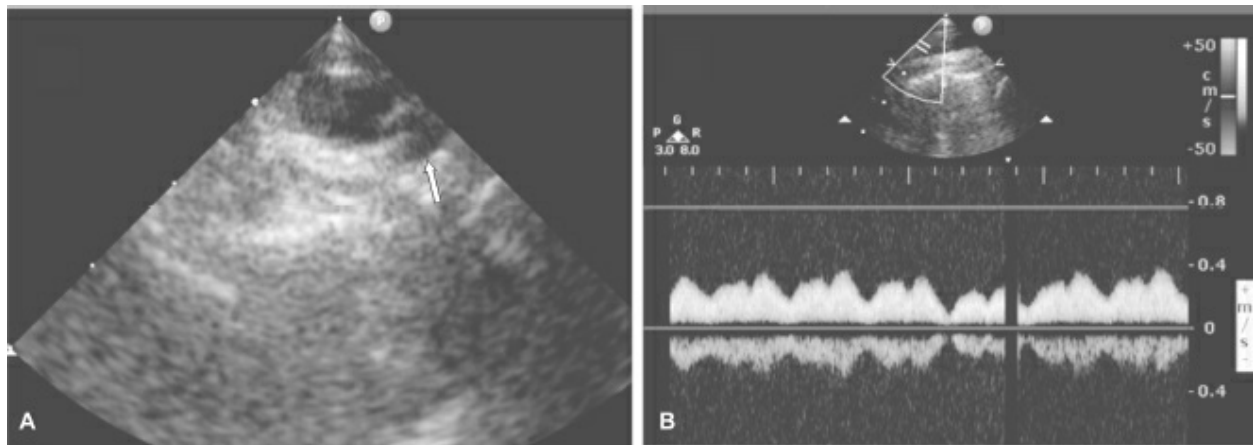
A: Ultrasound image showing transverse section of the right internal jugular vein seen as a central oval structure. The internal carotid artery (arrow) is seen medial and deeper to the vein. B: Pulsed wave Doppler profile obtained in the longitudinal section of the internal jugular vein. Note the continuous low velocity venous waveform
